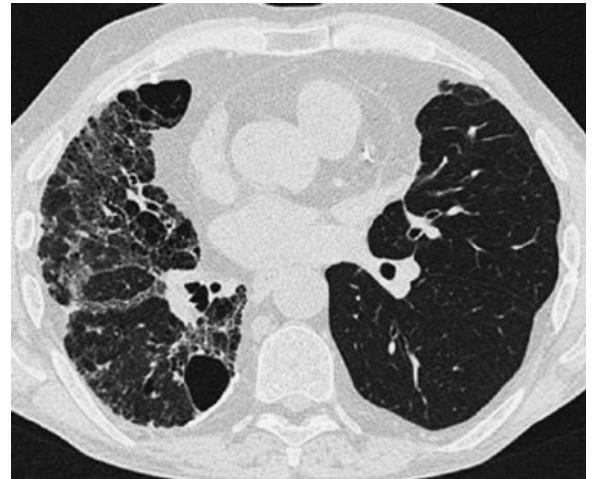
Transverse CT section in a single-lung transplant recipient. Native fibrotic lung (*right*) shows increased density, whereas the density of the transplanted left lung is normal
